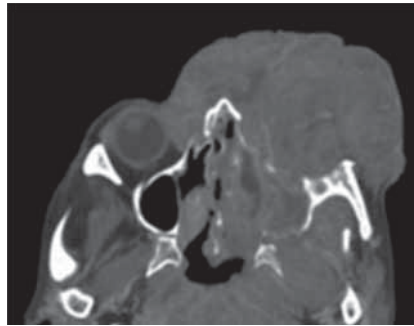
The axial image of CT scan showed a huge, ill-defined mass in the left orbital cavity. Left globe is pushed outside from its cavity and distorted in shape. It infiltrated into the subcutaneous tissue of nasal bridge.
